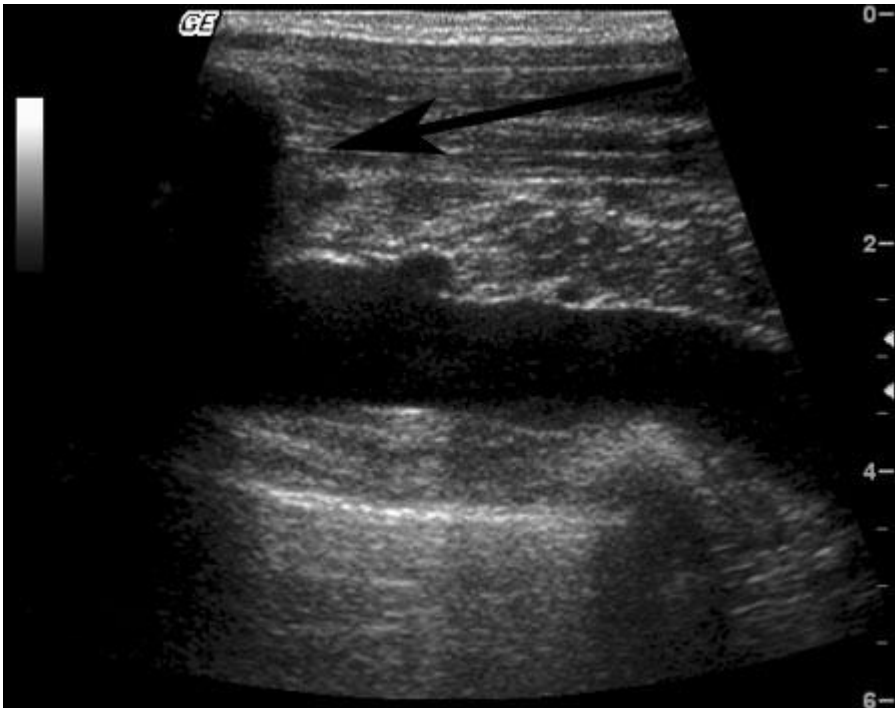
The portion of the subclavian vein cannot be imaged as it crosses under the clavicle (black arrow). Color Doppler evaluation cannot be used either. Doppler waveform analysis can help confirm the absence of an obstructing thrombus (figure 7a and 8). Smaller, non-obstructing thrombi could be missed since they would not perturb any blood flow patterns.
